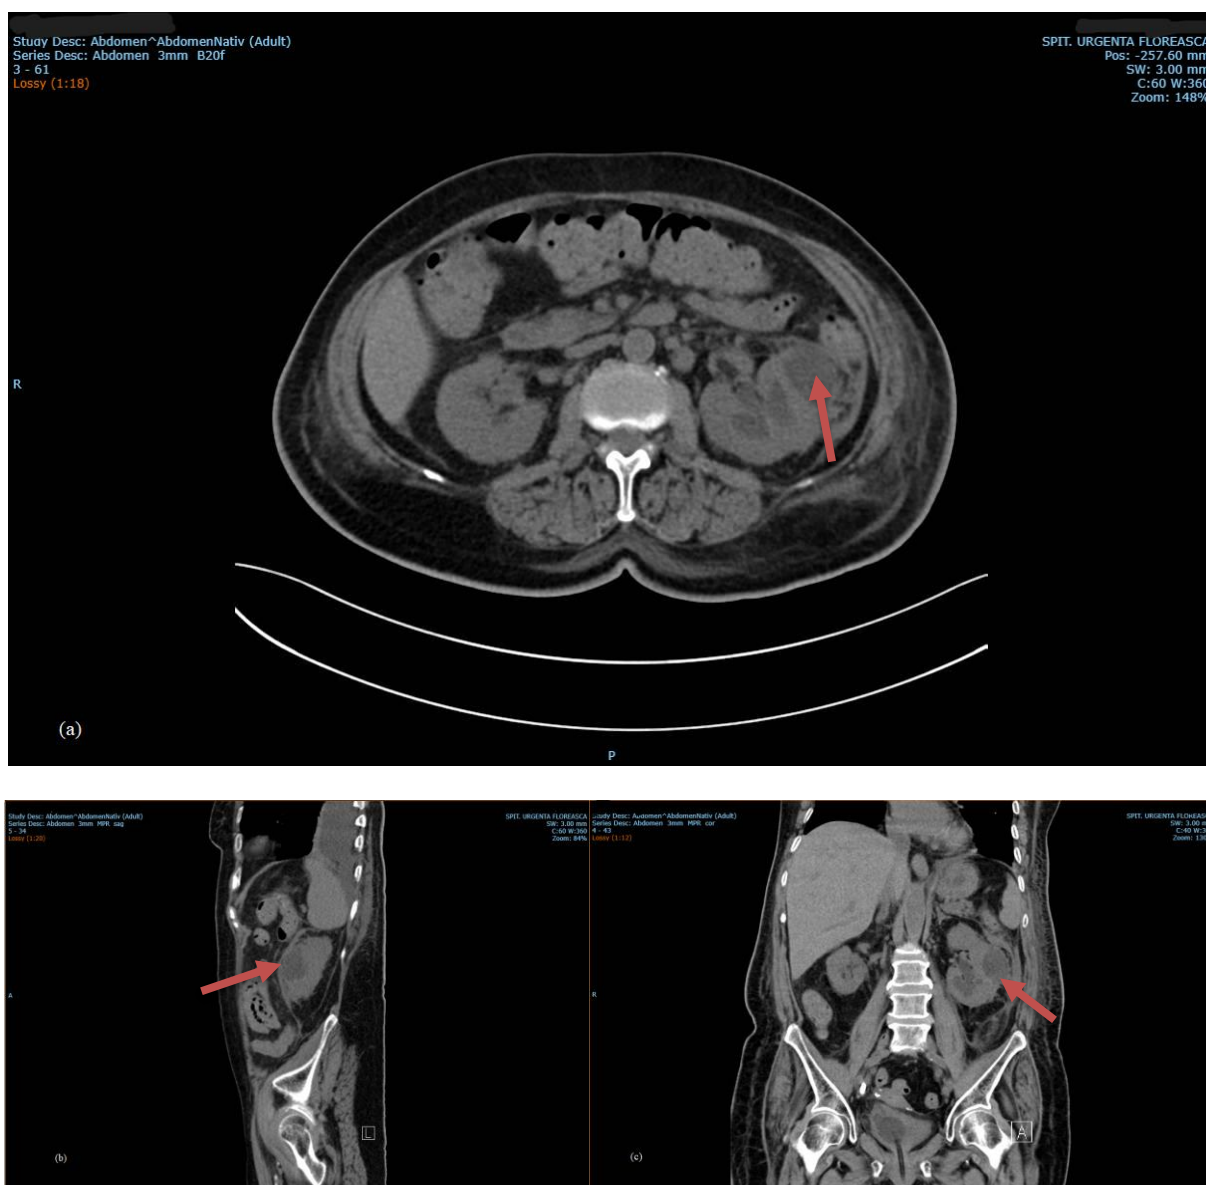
(a,b,c). Nonenhanced computed tomography (CT) images showing a well-defined mass of 35/30/47 cm on the left kidney, with low attenuation.
